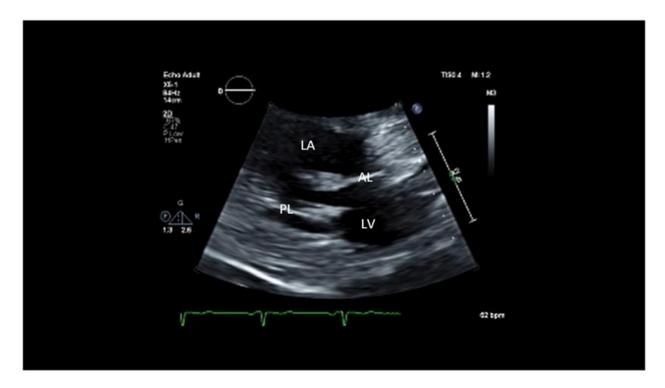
Transthoracic echo showed a mitral valve with a large (2.6 x 1.2cm) and a highly mobile homogeneous mass attached to the posterior leaflet and mildly thickenedanterior mitral leaflet. There is also mild mitral regurgitation and no mitral stenosis. LV-Left Ventricle; LA-Left Atrium; AL-Anterior Leaflet; PL-Posterior leaflet.
